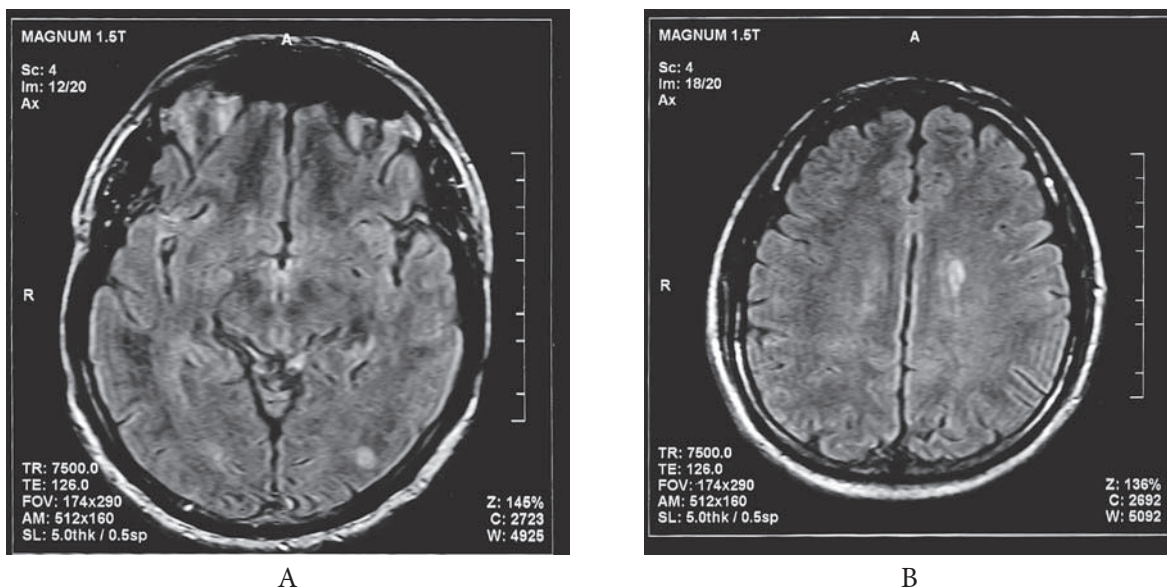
Magnetic resonance images without contrast enhancement before treatment showing a juxtacortical plaque (A) and periventricular plaque (B).
